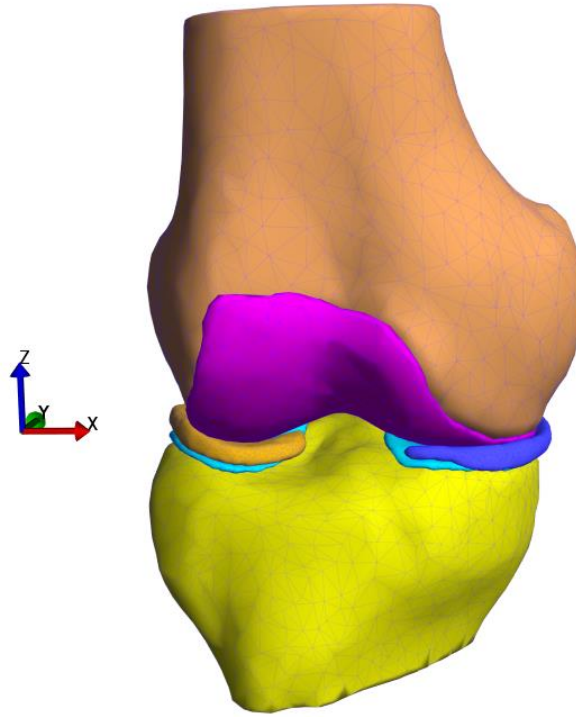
4. FEBio Model of female subject's knee using segmented geometry from MRI
